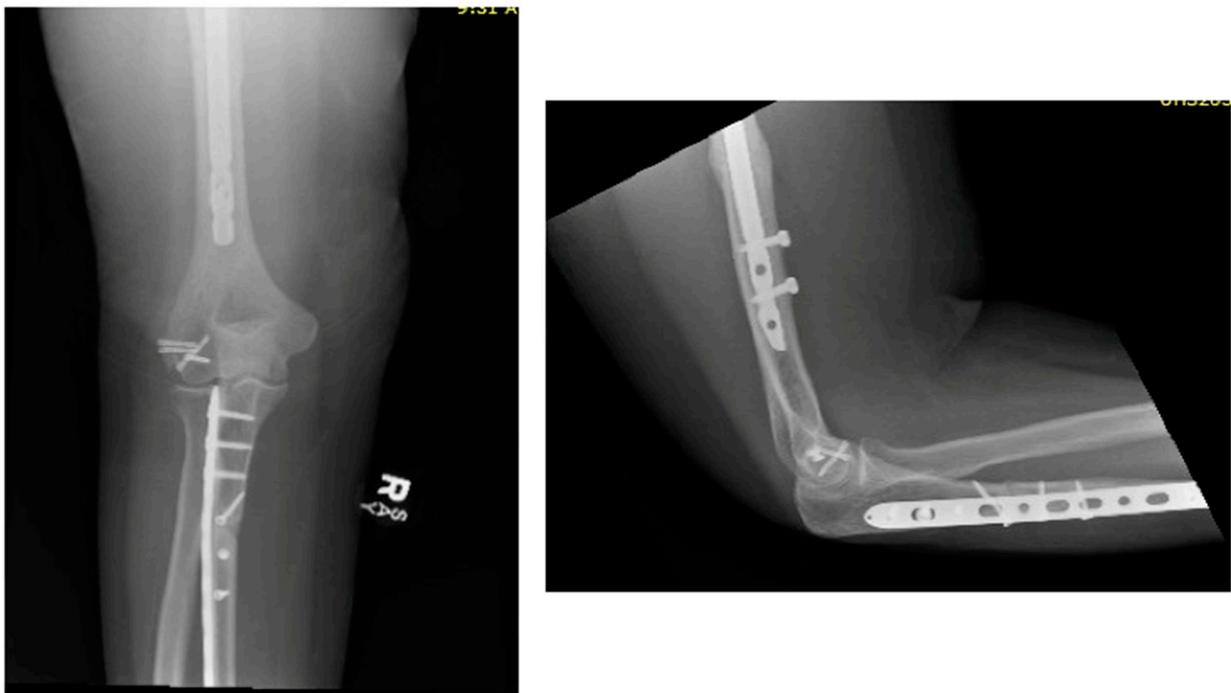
AP and lateral radiograph of right elbow demonstrating adequate reduction and healing at 6 months follow-up.
